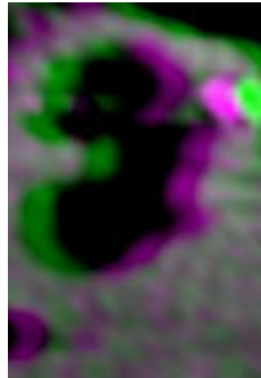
Example of the offset error which occurred between the 0° slice and the horizontally mirrored 180° slice. Intensity-Based Image Registration was used to calculate the offset, which was used to correct the offset when the AAM presents CT data between 180° and 360° , and between 540° and 720° .
